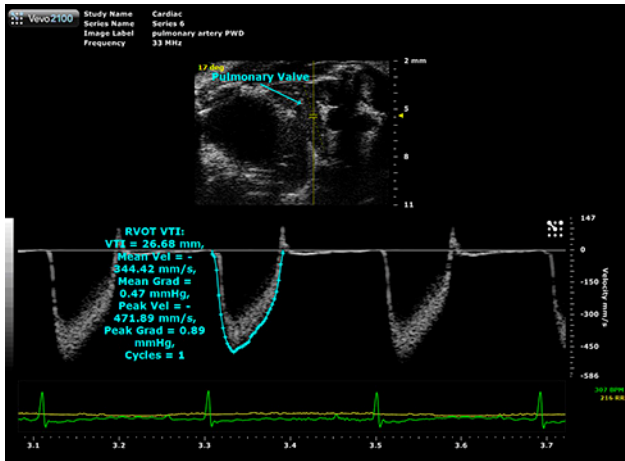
Pulsed Wave Doppler on the right ventricular outflow (RVOT) where the velocity time interval (VTI) is measured for inclusion in the pulmonary vascular resistance (PVR) calculation.
